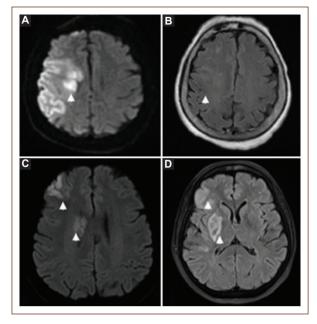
Magnetic resonance imaging in patients with acute ischemic stroke. Lesion shown on diffusion-weighted imaging (DWI) (A) but not on fluid attenuation inversion recovery (FLAIR) imaging (B); thus, it is considered a DWI-FLAIR mismatch. Meanwhile, the lesion on DWI (C) has a corresponding parenchymal hyperintensity on FLAIR (D), so there is no mismatch.
